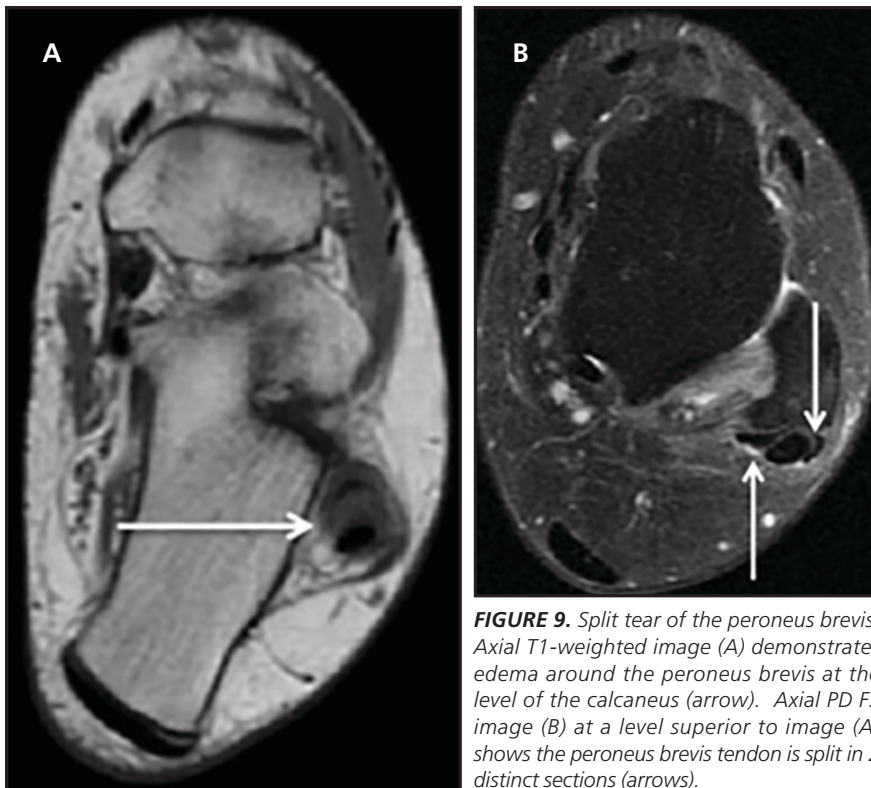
Split tear of the peroneus brevis. Axial T1-weighted image (A) demonstrates edema around the peroneus brevis at the level of the calcaneus (arrow). Axial PD FS image (B) at a level superior to image (A) shows the peroneus brevis tendon is split in 2 distinct sections (arrows).
